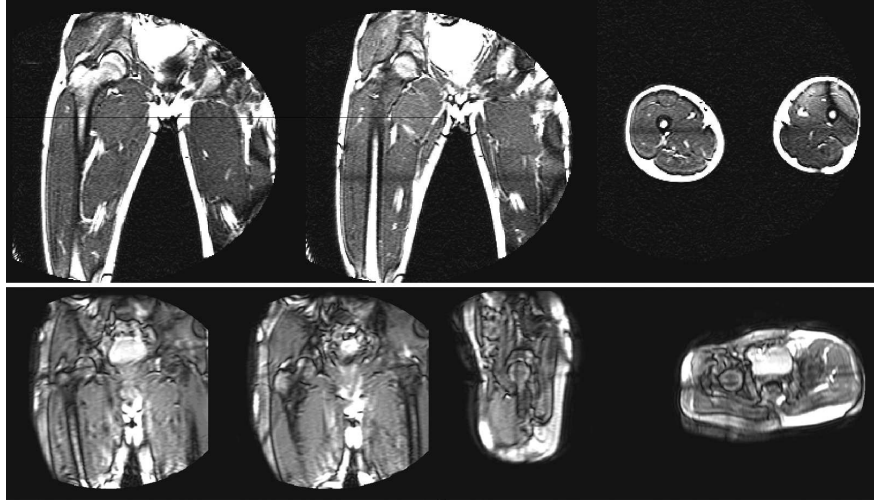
Dynamic MRI protocols for the hip
